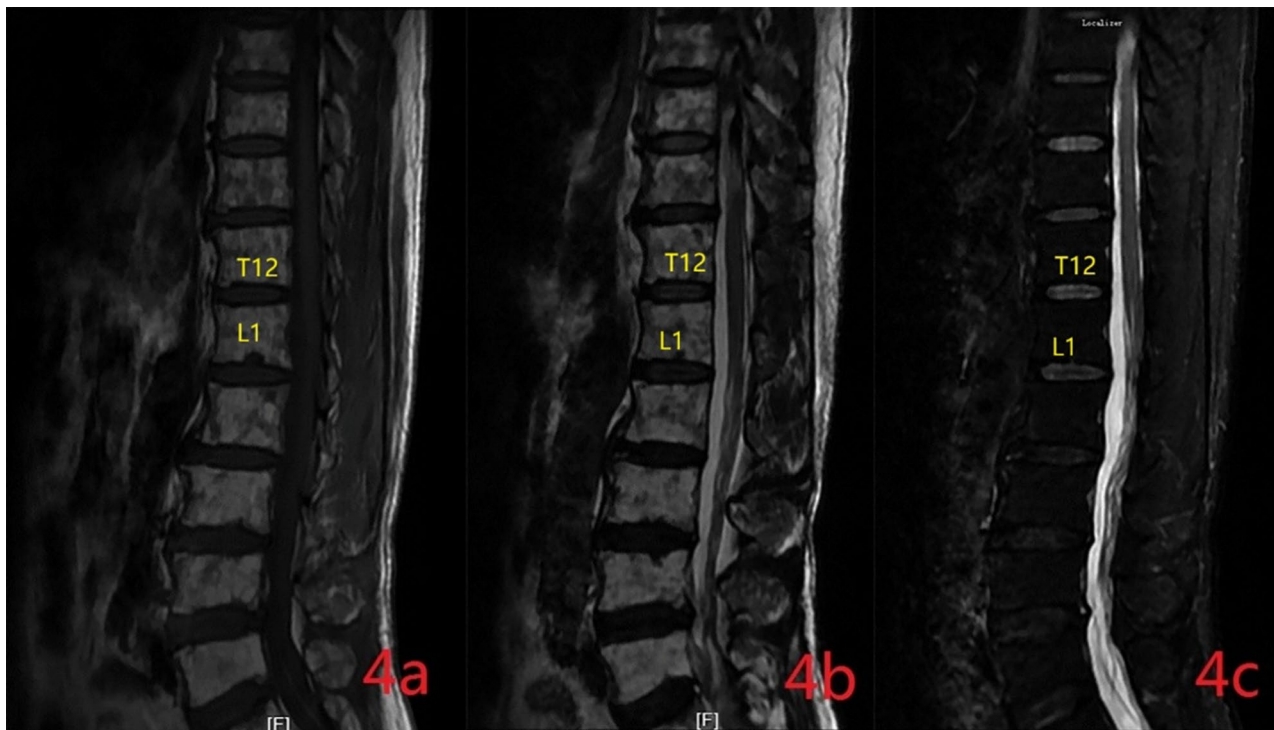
Thoracolumbar magnetic resonance imaging without contrast (on day 20 after symptom onset). 4a: T1WI of the thoracolumbar spine demonstrates that the previously observed epidural hematoma has now completely resolved. 4b: T2WI of the thoracolumbar spine demonstrates that the previously observed epidural hematoma has now completely resolved. 4c: T2WI + FS of the thoracolumbar spine demonstrates that the previously observed epidural hematoma has now completely resolved
